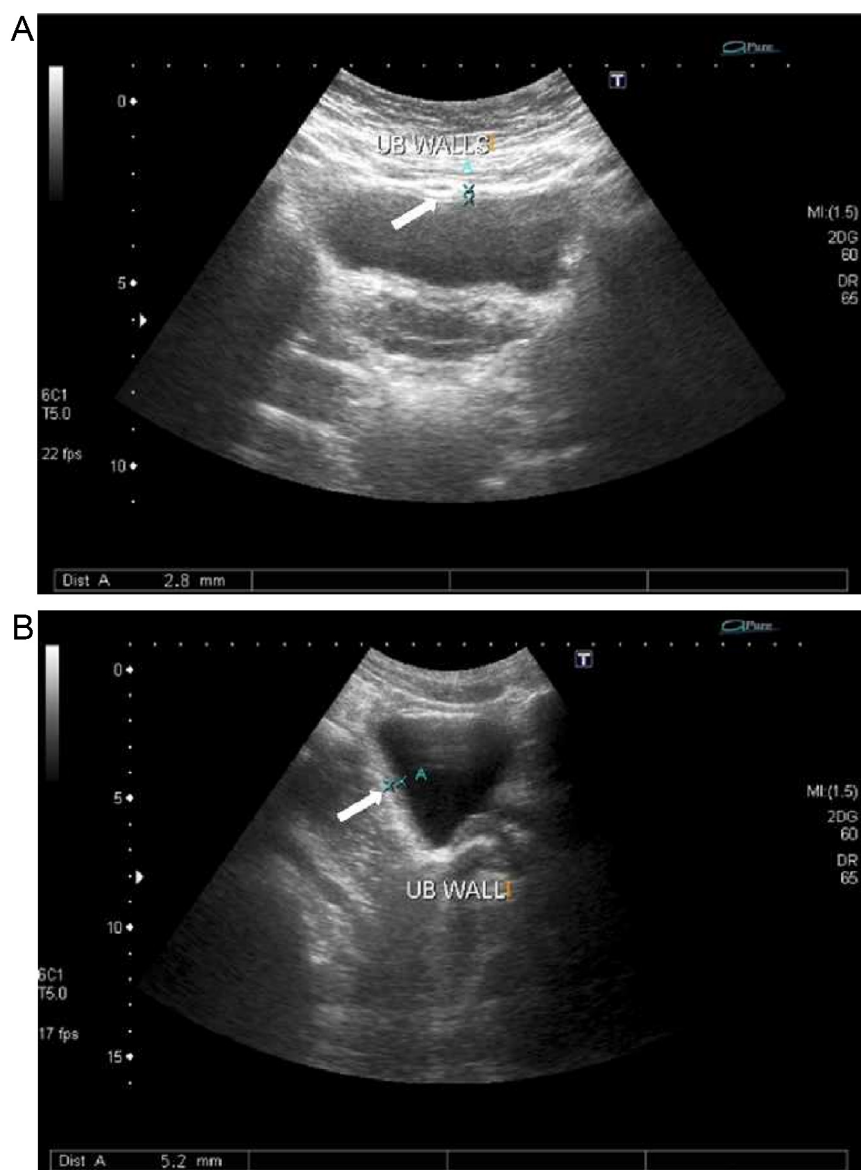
(A) An ultrasound image of the urinary bladder (transverse scan) showing normal bladder wall thickness (BWT) (a, arrow) in a middle-aged woman with irritative lower urinary tract symptoms (LUTS) and normal filling cystometry (FCM); (B) Ultrasound image (longitudinal scan) showing increased BWT (b, arrow) in a middle-aged man with irritative LUTS and detrusor overactivity diagnosed by FCM.
